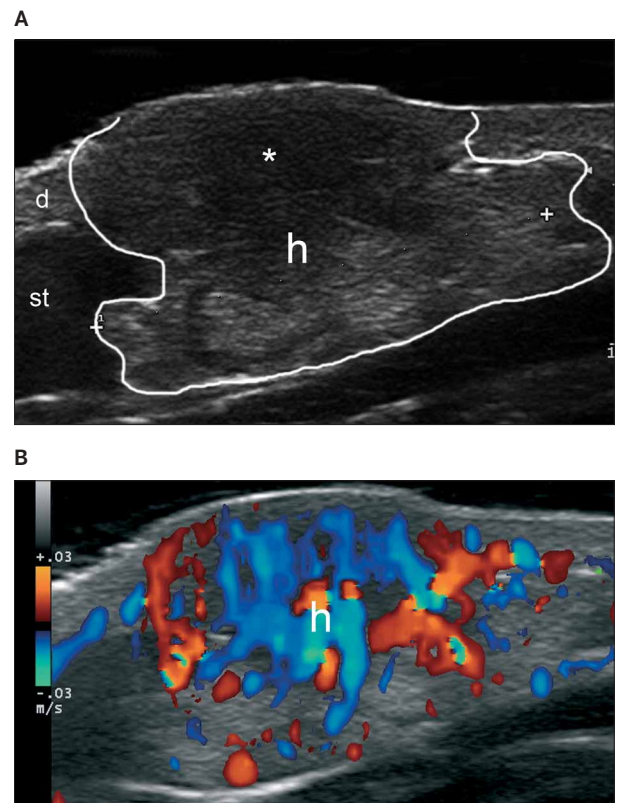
Hemangioma. A, Gray scale sonography (right dorsal region, transverse view) shows a poorly defined heterogeneous lesion (outlined) in the dermis and subcutaneous tissue. Notice the more hypoechoic area (asterisk) in the upper part of the lesion, which corresponds to the most proliferative zone. B, Color Doppler sonography shows increased vascularity within the same lesion. Abbreviations: d indicates dermis; h, hemangioma; and st, subcutaneous tissue.
